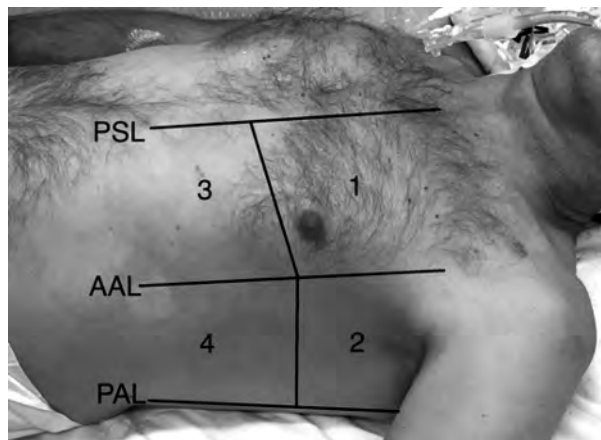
Left lung divided into 4 quadrants. PSL: parasternal line; AAL: anterior axillary line; PAL: posterior axillary line
